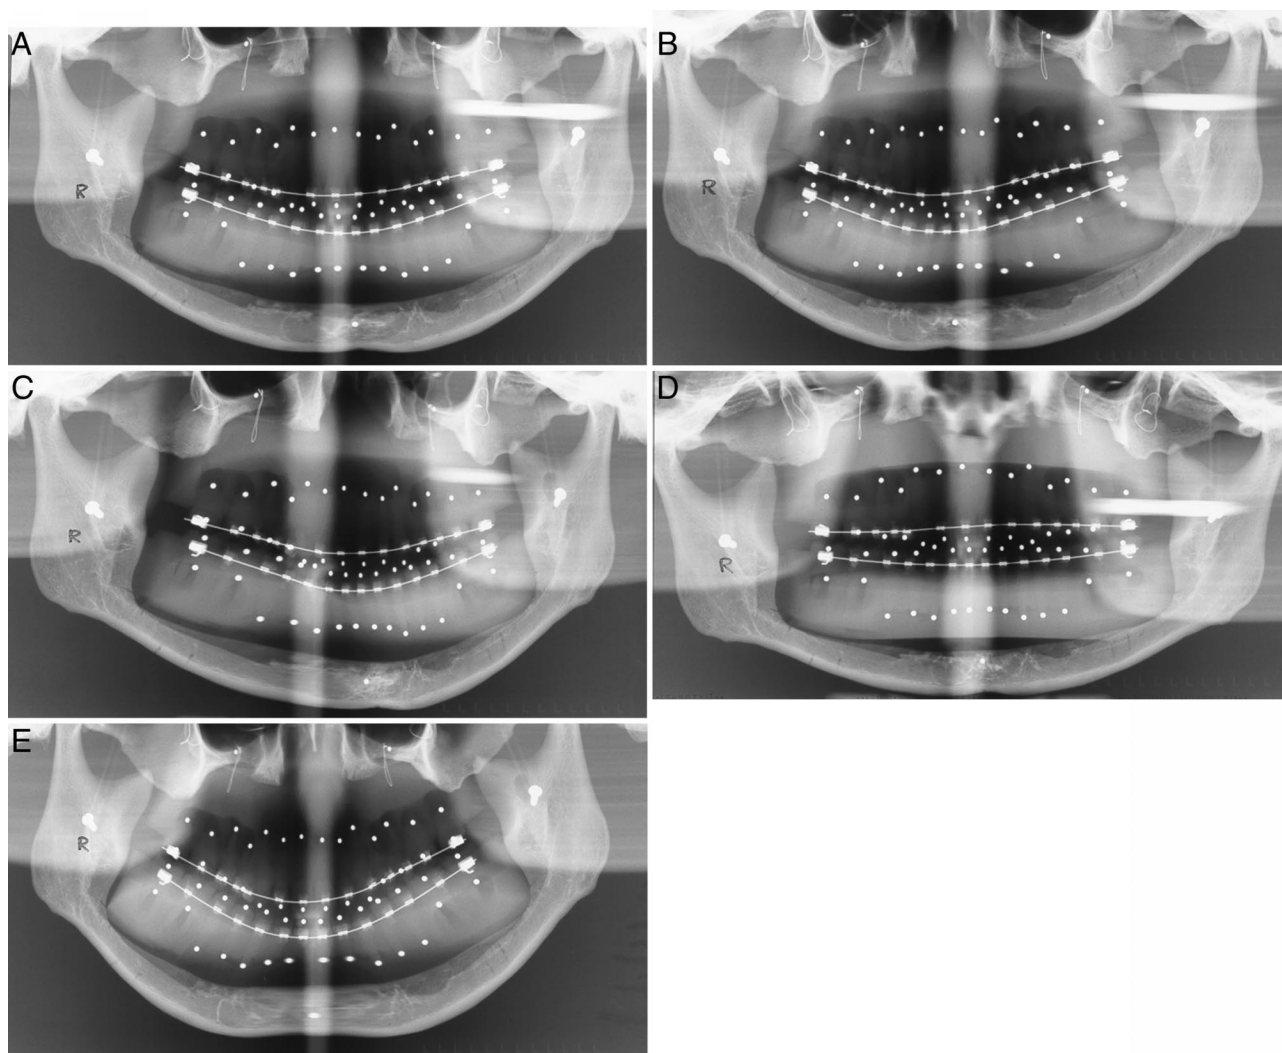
Panoramic images from the Orthopantomograph OP 100 at each of the 5 head positions. (A) Ideal head position. (B) 5° right. (C) 5° left. (D) 5° up. (E) 5° down.
